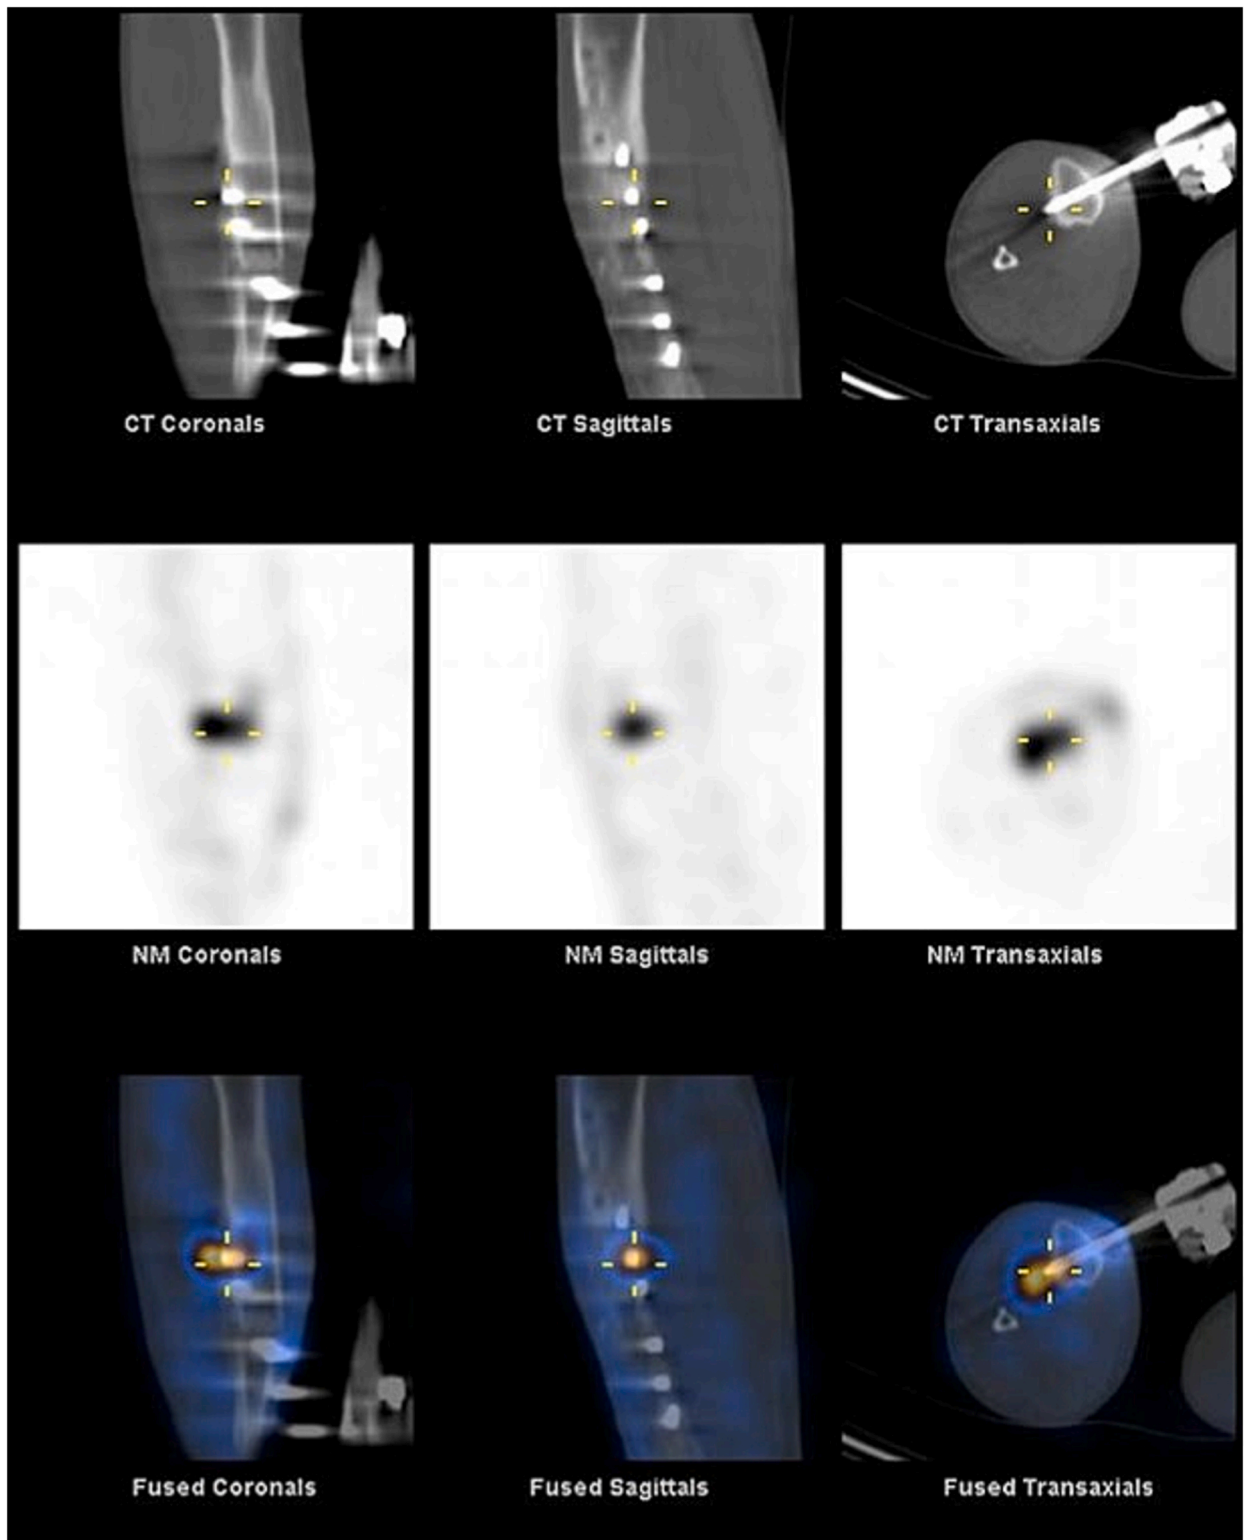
SPECT-CT scan showing signs of pin tract infection but no sepsis at the nonunion site.
